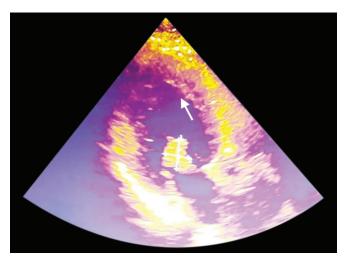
Transthoracic echocardiography showing a small irregular mass on free edge of posterior mitral leaflet measuring 2.1×1.6 cm
